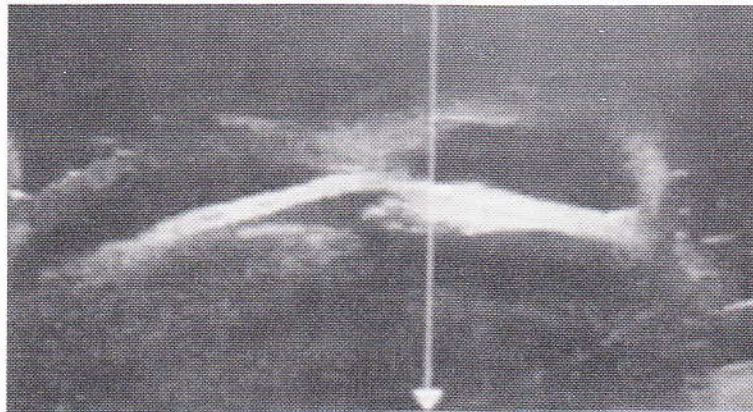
Pre Operative ultrasound showing cystic space in limbal area
